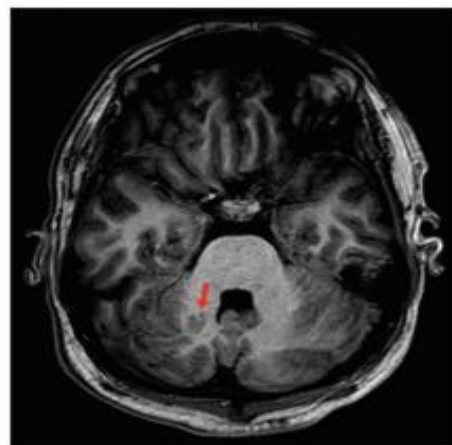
Epilepsy 3T magnetic resonance imaging showing focal subcortical heterotopia of the right cerebellar hemisphere.
